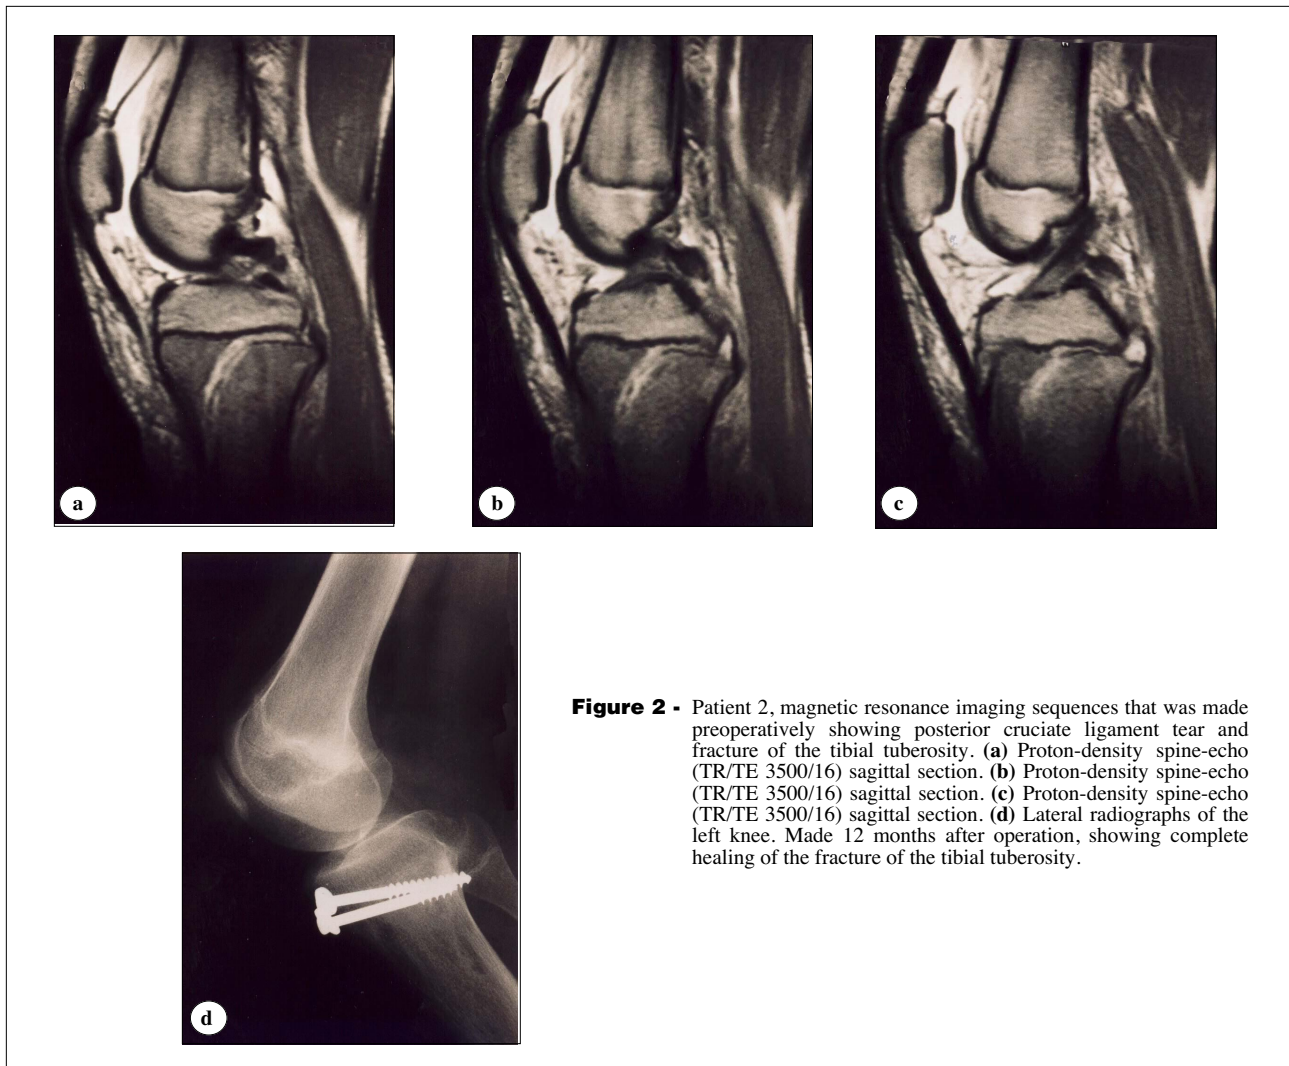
Patient 2, magnetic resonance imaging sequences that was made preoperatively showing posterior cruciate ligament tear and fracture of the tibial tuberosity. (a) Proton-density spine-echo (TR/TE 3500/16) sagittal section. (b) Proton-density spine-echo (TR/TE 3500/16) sagittal section. (c) Proton-density spine-echo (TR/TE 3500/16) sagittal section. (d) Lateral radiographs of the left knee. Made 12 months after operation, showing complete healing of the fracture of the tibial tuberosity.
